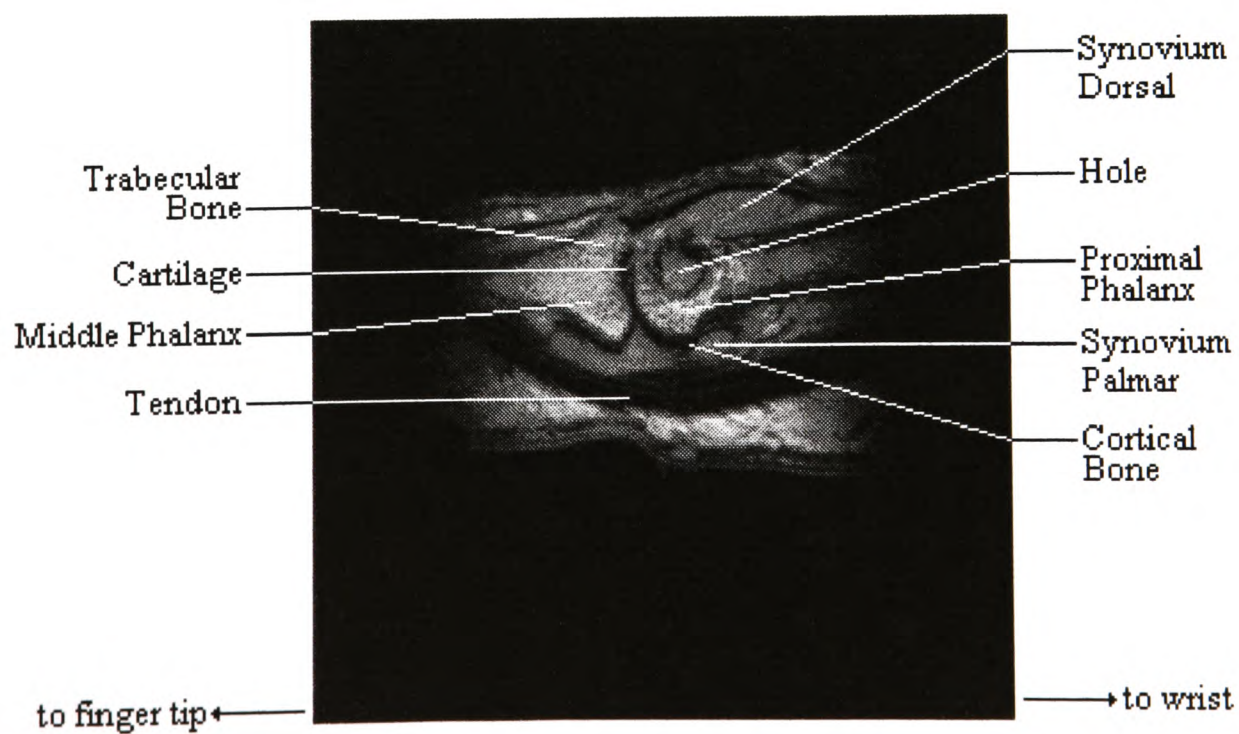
MRI scan of an RA patient.
